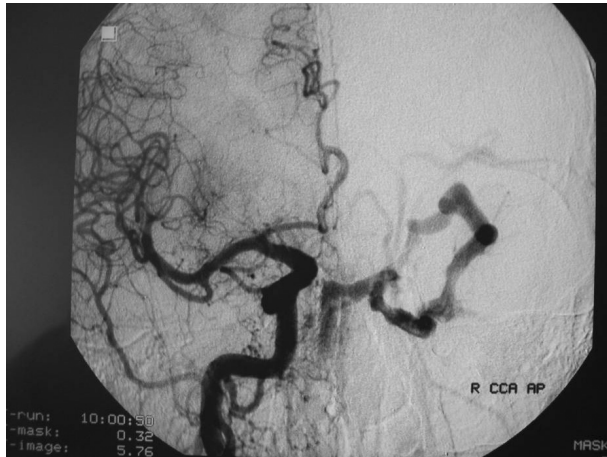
B: Cranial MRI and angiography examinations detecting fistula a
